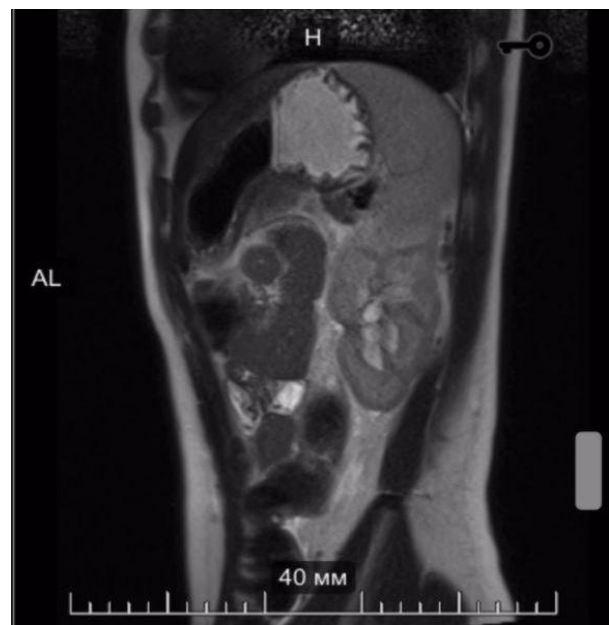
Anterolateral view of MRI of abdomen.
